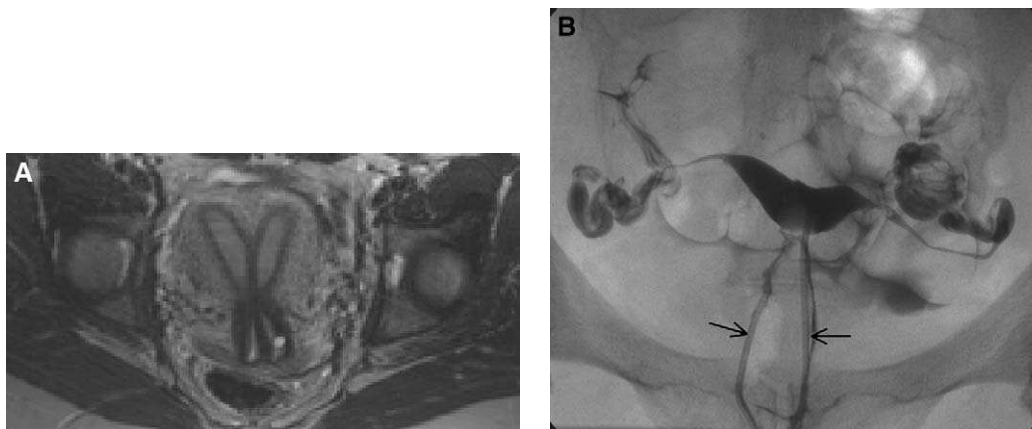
Septate uterus. (A) Complete uterine and cervical septum by MR imaging. (B) Postoperative hysterosalpingogram demonstrates normal cavity after resection of uterine septum; cervical septum was not resected to avoid incompetent cervix. Two cervical canals are demonstrated (arrows).
